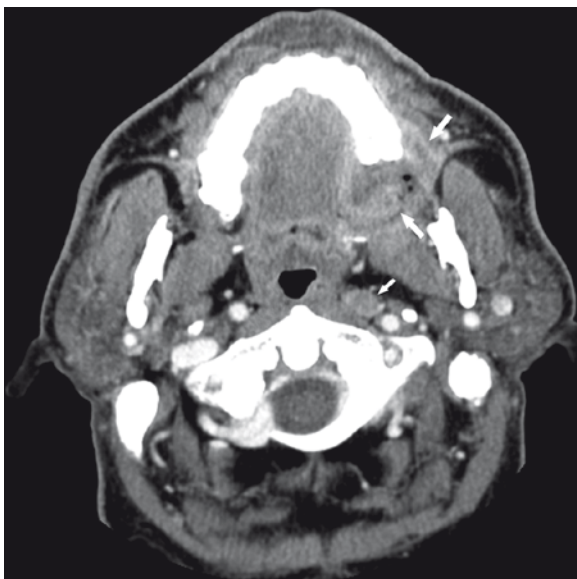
Metastatic lateral retropharyngeal node of Rouviere in maxillary alveolar ridge carcinoma. Axial CT image shows the obvious primary along the posterior maxilla (*large arrows*) and an enlarged, perhaps subtly necrotic left-sided lateral retropharyngeal lymph node (*small arrow*)
